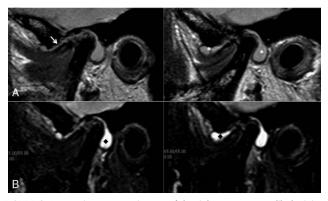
Magnetic resonance images of the right temporomandibular joint. [Sagittal view-closed-mouth position] (A) T1-weighted sequence showing advanced destruction of the articular disc anteriorly displaced (arrow), erosion in the upper surface of the condyle and articular eminence, and distinct nodules within an extremely expanded inferior joint compartment with large amount of fluid (*). (B) T2-weighted sequence showing great amount of the fluid inside of the joint (ϕ).
